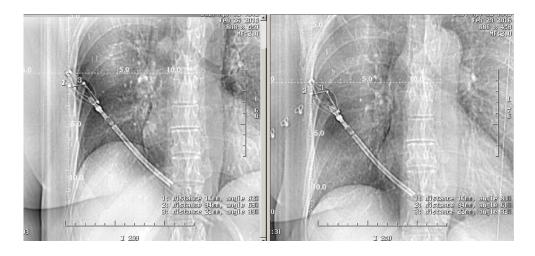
Pre-fractional comparison and review of implant placement: daily CT scout (right image) compared against original planning CT scout (left image)
